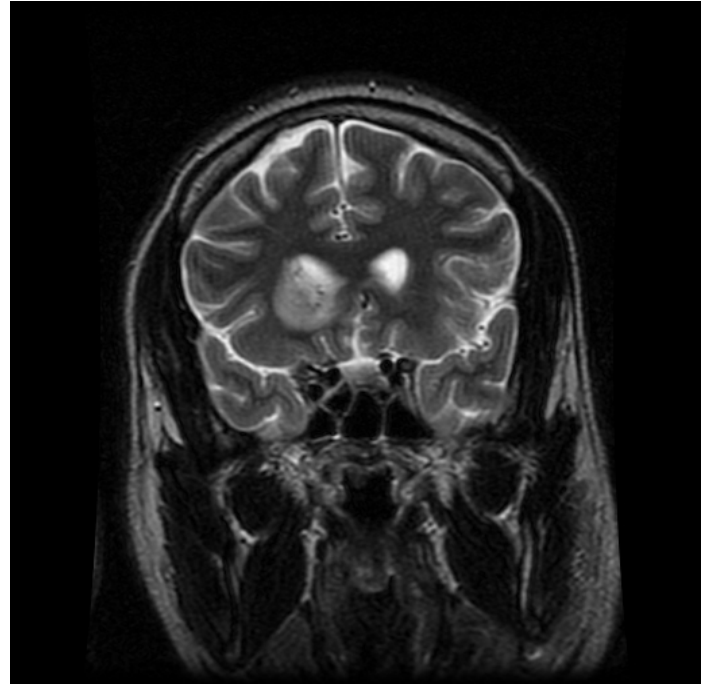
Brain MRI (T2 coronal image) showing a mass-like abnormal signal changes in the right caudate nucleus with extension to adjacent periventricular white matter .
